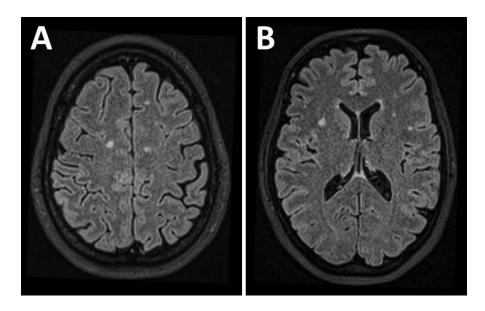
Axial fluid-attenuated inversion recovery brain MRI images of a migraine patient with aura. The figure shows bifrontal white matter hyperintensities in two different slices (A and B).
